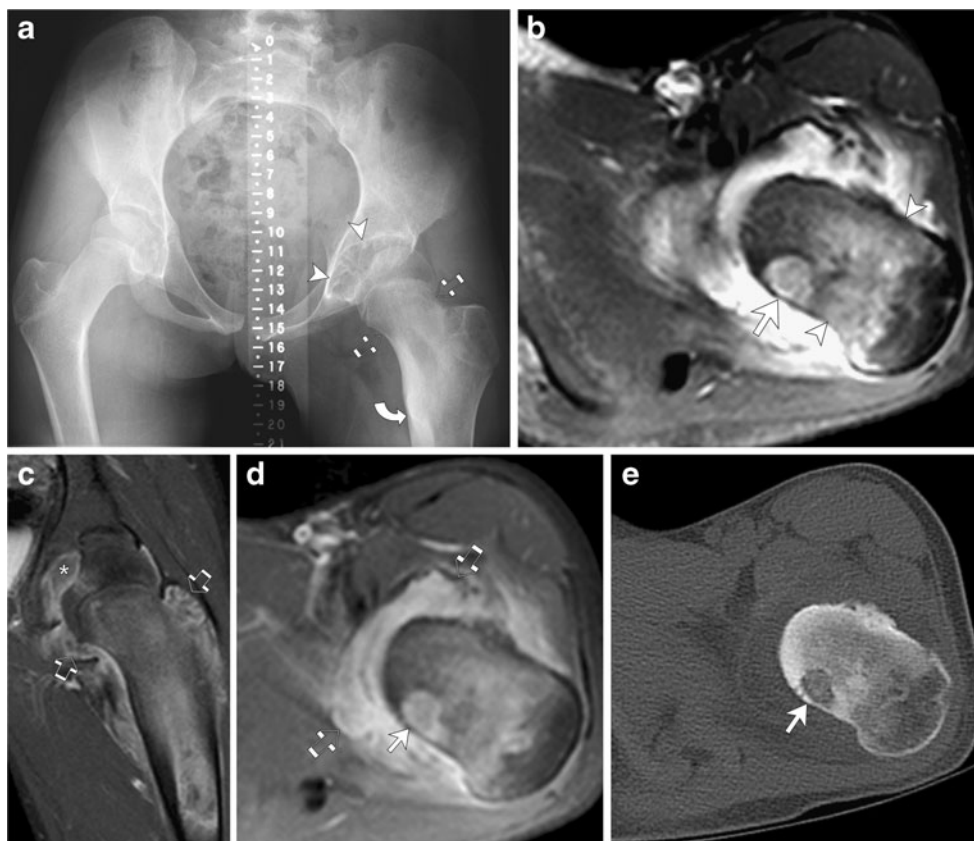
Intra-articular osteoid osteoma in a 12-year-old girl with leg length discrepancy and hip joint contracture. a AP radiograph of the pelvis shows osteopenia of the left proximal femur with shortening and widening of the femoral neck (*straight arrows*). There is medial cortical thickening of the proximal femur (*curved arrow*). The left hip joint is widened with erosive changes of the acetabulum, suggestive of a joint effusion and synovitis (*arrowheads*). There is a 0.7-cm leg length
